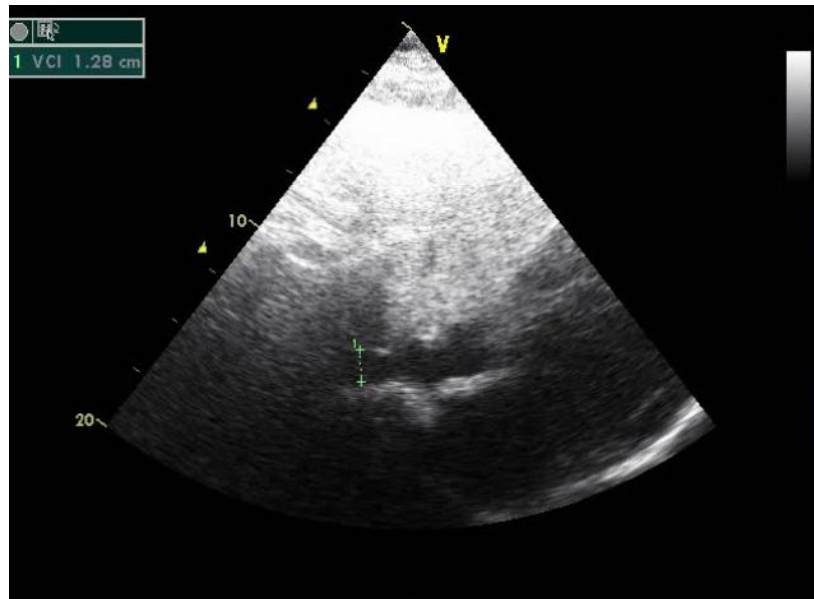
Estimation of IVC diameter during quite expiration by 2D echocardiography
